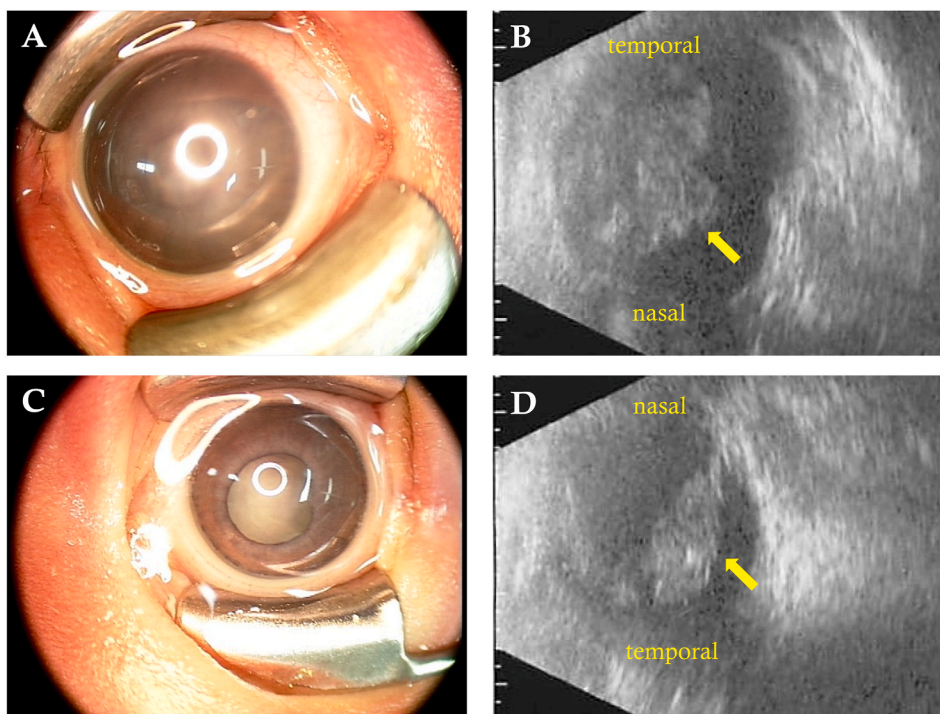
Case 1: pre-operative findings. The right eye had a significant corneal opacity and a flat anterior chamber with iris adhesions to the cornea (A). B-scan ultrasonography revealed a total retinal detachment (arrow) (B). The left eye presented with rubeosis iridis (C), a fibrovascular stalk, and a total retinal detachment (arrow) (D).
